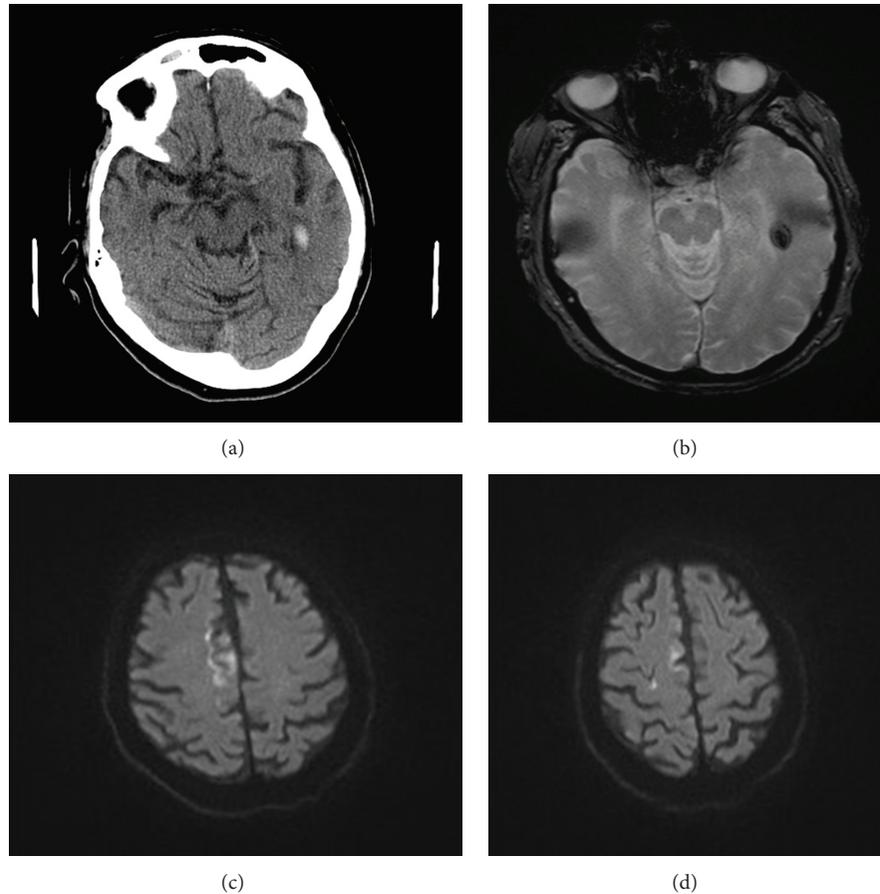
Subject presented with acute left hemiparesis, leg more affected than arm. Routine day one CT (a) and day 5 MRI (b) demonstrate a small haemorrhage in the left temporal lobe, away from the main area of infarction, shown on diffusion weighted MRI (c) and (d), mainly in the territory of the right anterior cerebral artery. No clinical deterioration was detected.
